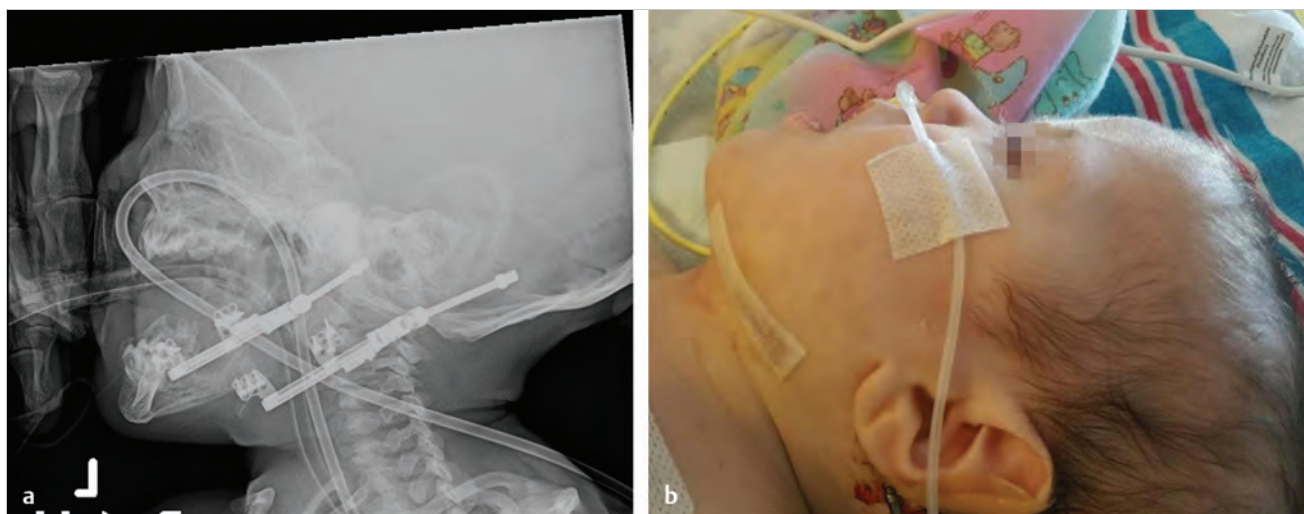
Lateral radiograph showing device placement with distracted mandibular segments and clinical image of infant during the consolidation period.
